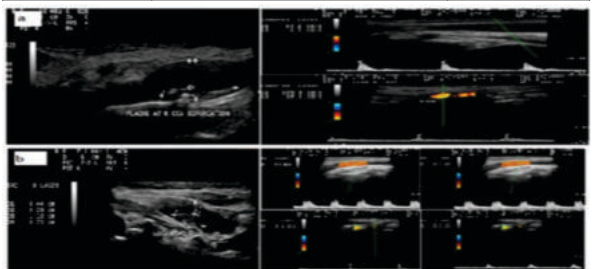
(a) Gray scale sonography image showing hyperechoic smooth
